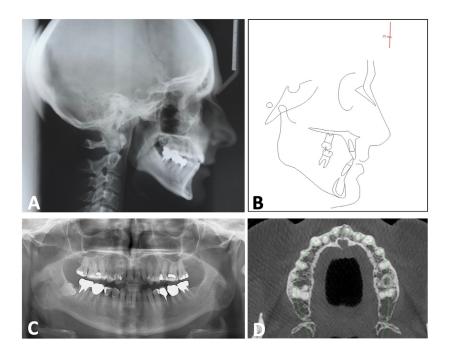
Pretreatment records: A, Lateral radiograph; B, Lateral cephalometric tracing; C, Panoramic radiograph; D, CBCT axial slice.
